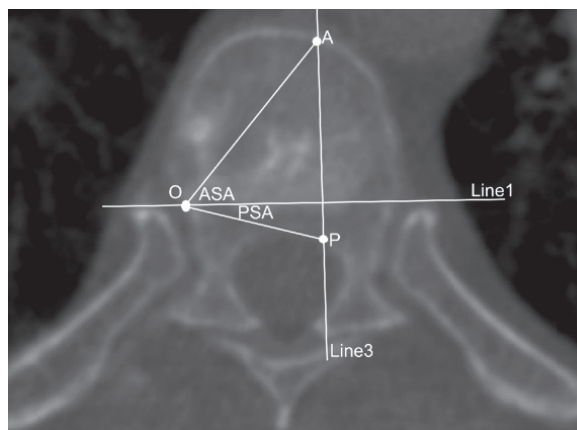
The posterior safe angle (PSA) and anterior safe angle (ASA) (transverse CT). "P" is the most antero-lateral aspect (concave side) of the spinal canal. "Line 3" is a line through P, perpendicular to "Line 1" and tangential to the lateral margin of the concave spinal canal. The PSA is the angle subtended by "Line 1" and a line drawn from the convex rib head ("O") to "P". "A" is the point that "Line 3" intersects the anterior margin of the vertebral body. ASA is the angle subtended by Line 1 and a line drawn from the convex rib head to "A".
